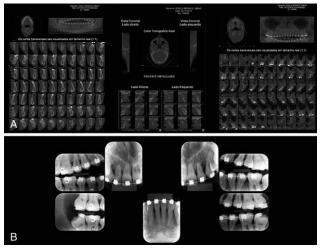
Orthodontic records to support the surgery. (A) Preoperative conebeam computed tomography. (B) Preoperative periapical radiographs.
